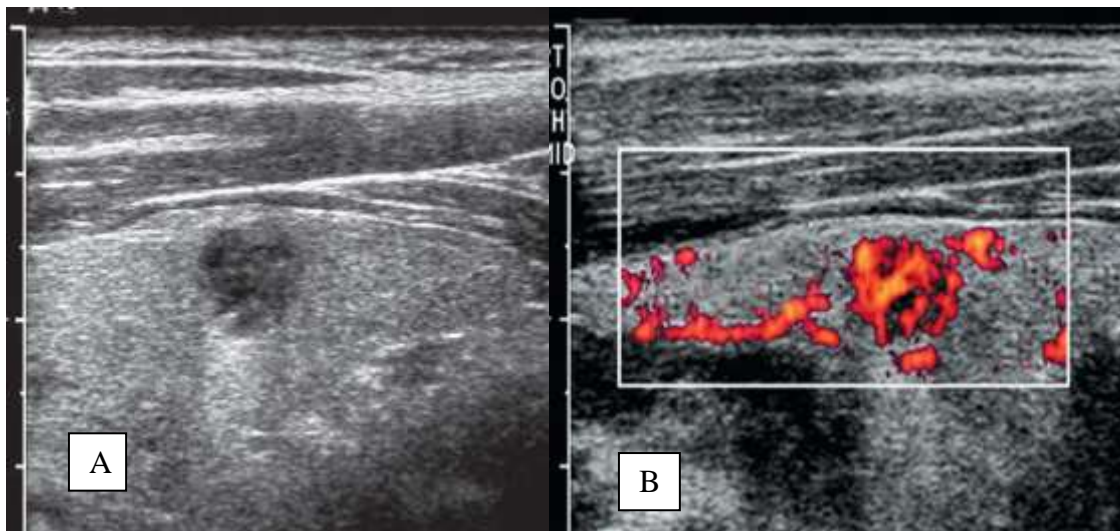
Thyroid metastasis from renal cell carcinoma. *A, Longitudinal (gray scale), and B, power Doppler, images show a 1-cm solid vascular mass.*
